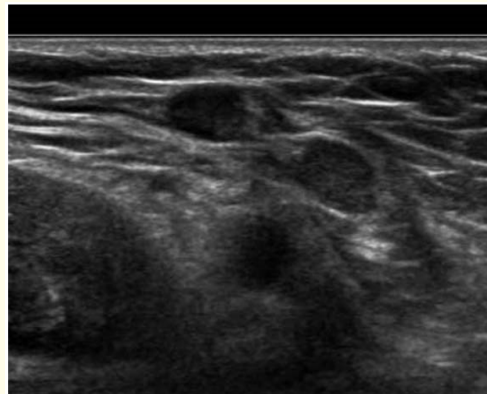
Ultrasound of right inguinal canal demonstrating enlarged inguinal lymph node.
